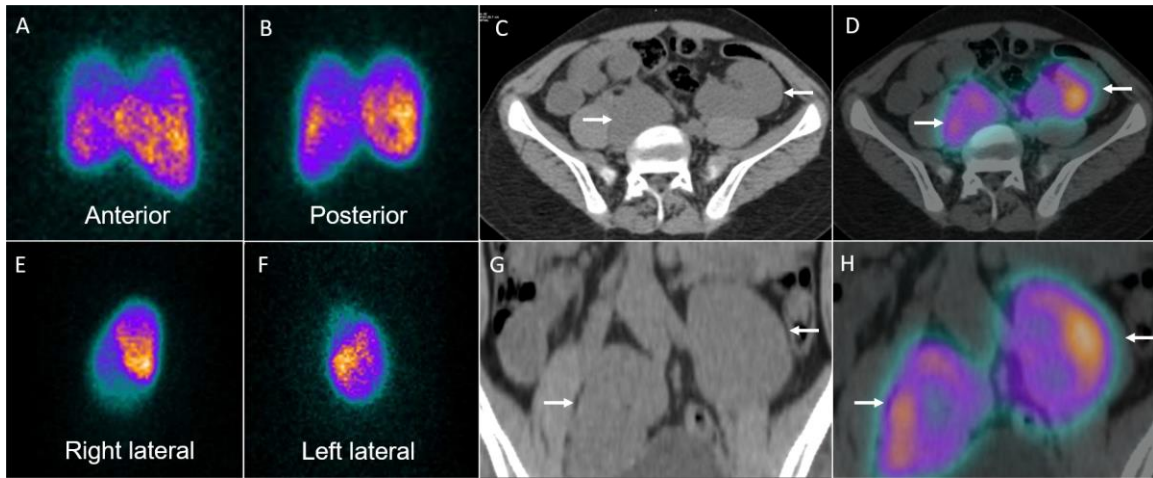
DMSA planar scan in anterior, posterior, right, and left lateral views (A-B, E-F) revealed bilateral low-lying kidneys in the paramedian location with both the kidneys to be apparently fused in the midline. Single photon emission computed tomography with low-dose computed tomography (SPECT/CT) was acquired which revealed bilateral low-lying pelvic kidneys in the paramedian location that was clearly separate from each other on trans-axial and coronal CT (C, G, arrows) sections with corresponding fused SPECT/CT images (D, H, arrows).
